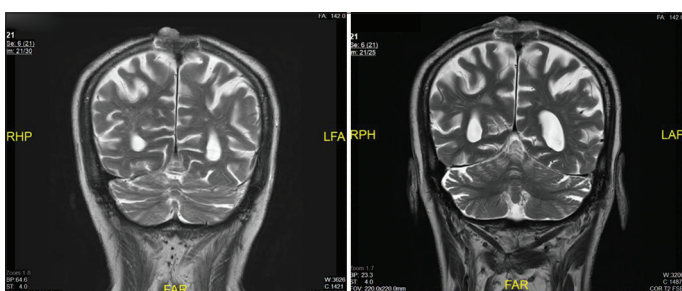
Magnetic resonance imaging brain at 2nd recurrence
